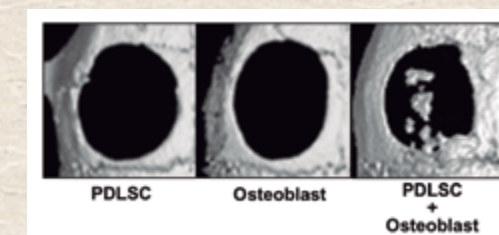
Micro CT images of bone defects 4 weeks after the transplantation of cell-transferred amnion. In the single cell transplantation (mesenchymal stem cells from periodontal ligament (PDLSC) or osteoblast), bone healing was limited while new bone-like tissue formation was observed in bone defects transplanted with double-layered cell-transferred amnion (PDLSC+Osteoblast).
